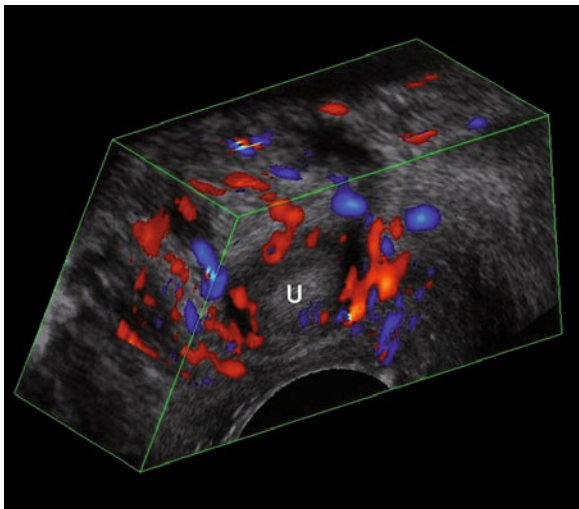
Three-dimensional color Doppler imaging. Spatial distribution of the urethral vessels. Image obtained by 8848 transducer (B-K Medical). *U*, urethra
